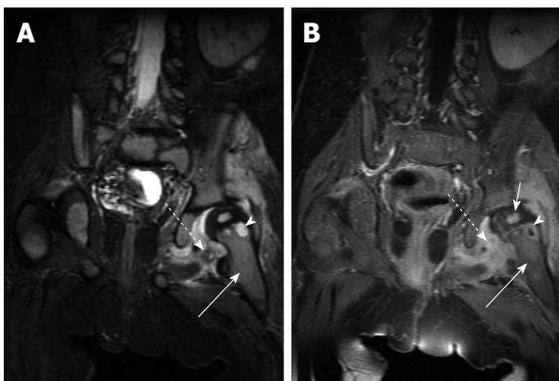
Acute osteomyelitis of the hip. A: Coronal fast spin echo inversion recovery image shows T2-hyperintense marrow edema in the left femoral metaphysis (solid arrow) with a small round very intense focus of T2 signal (arrowhead) which is consistent with an intraosseous abscess. Surrounding soft tissue edema (dashed arrow) is also noted; B: Coronal T1-weighted post-contrast image in the same patient shows enhancement in the metaphyseal bone marrow (solid long arrow), peripheral enhancement of the abscess (arrowhead), and surrounding soft tissue enhancement (dashed arrow). Note enhancement of the left femoral head (solid short arrow) which indicates adequate perfusion.
